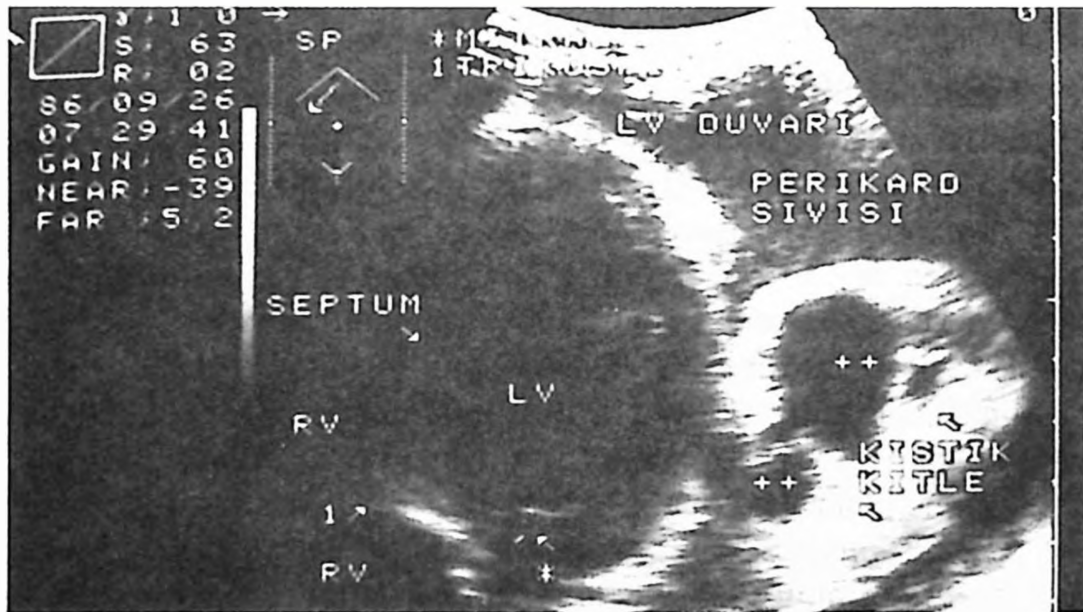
The appearance of pericardial fluid and cystic mass on parasternal short axis examination
